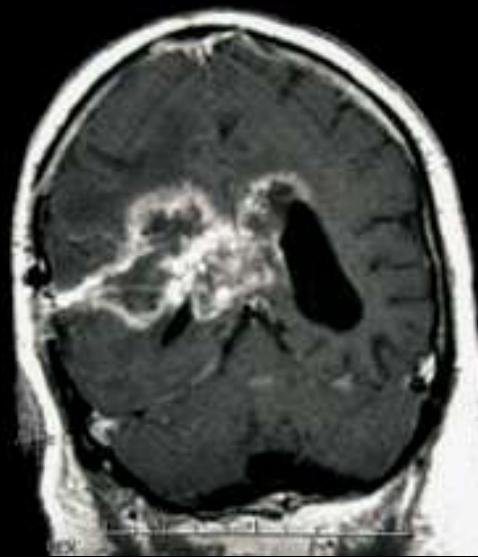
T1-weighted MRI with gadolinium contrast showing a typical appearance of a glioblastoma multiforme. Non-contrast-enhanced images of this lesion (not shown) revealed the presence of some hemorrhage.
